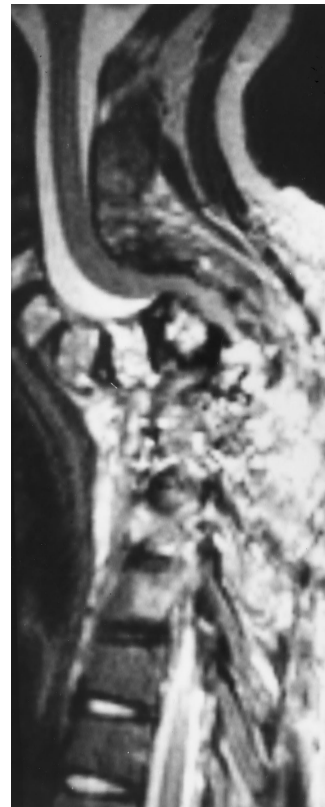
Case 2. Magnetic resonance imaging of the cervicothoracic spine. Note narrowing of the spinal canal with the cord draped over the kyphotic deformity and abnormal signal in the bone marrow from C4 to T3.
